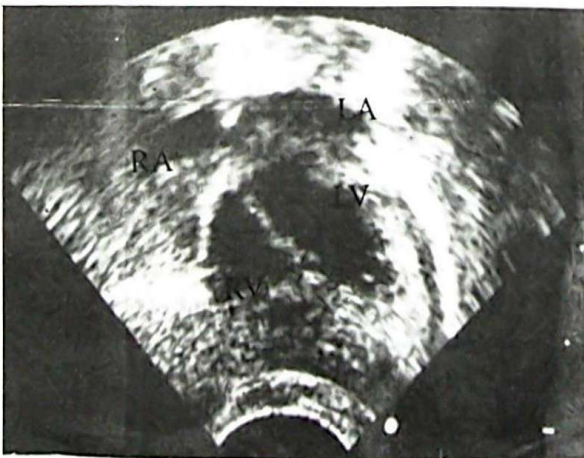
Echocardiographic findings showing resolution of vegetation after treatment
